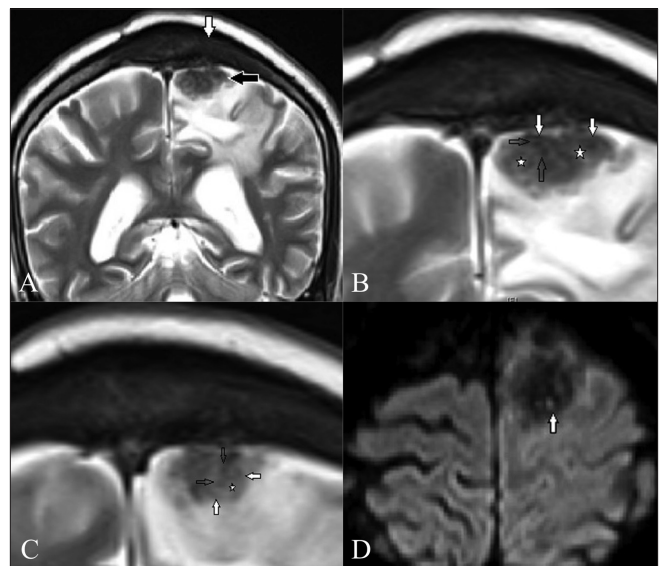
(A,B): Axial FLAIR (A) and T2W (B) MRI images show a conglomeration of multiple extremely hypointense dots (arrows) within an iso- to hypointense mass in the left parasagittal frontal lobe, involving the motor cortex
